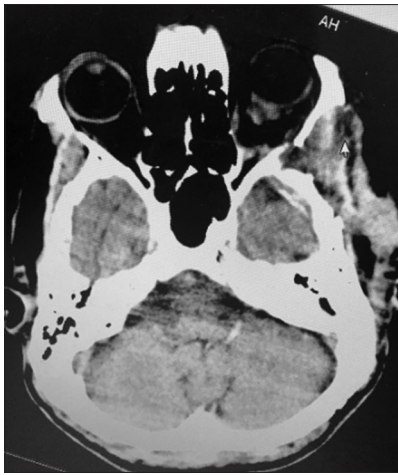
Computed tomography scan showing near total excision of left orbital intraconal tumor (CT – Computed tomography)
